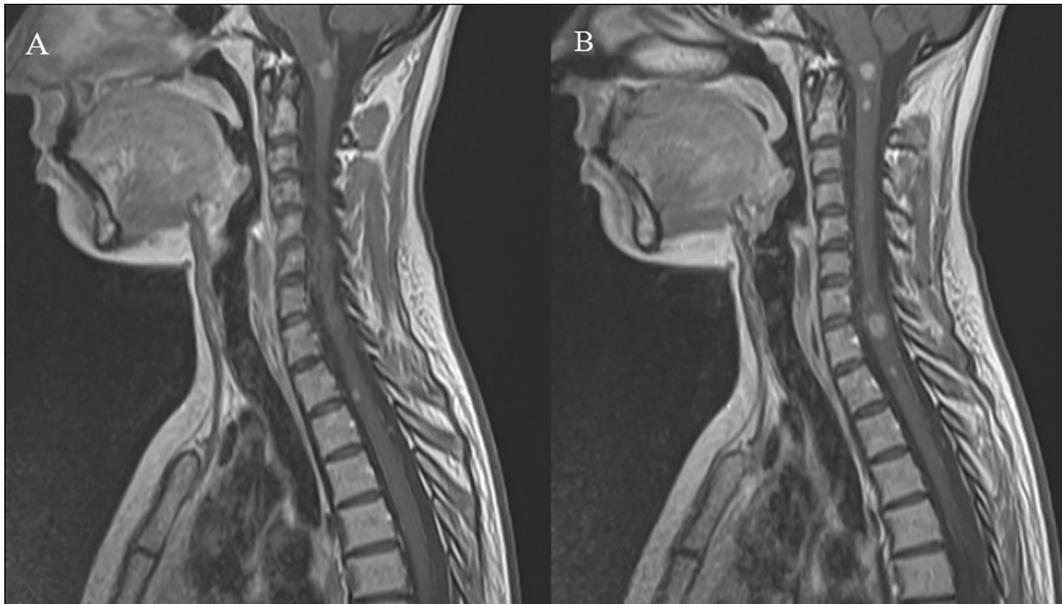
MRI, T1 + Gd: multifocal spinal cord lesion in a patient with NF2.
